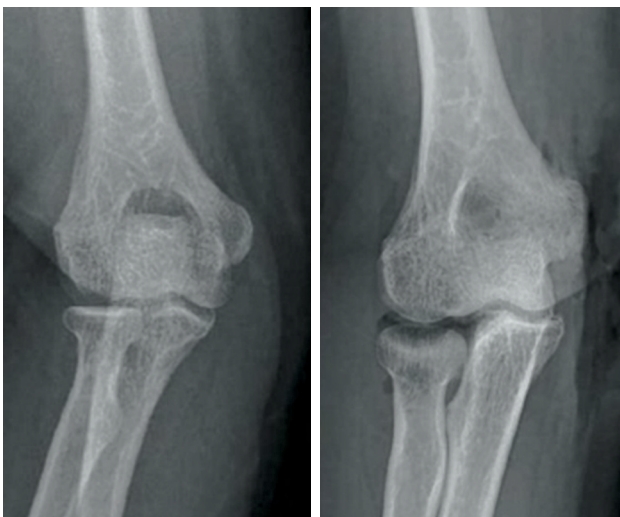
Pre- and postoperative anteroposterior radiographs of a patient who had partial medial epicondylectomy.
